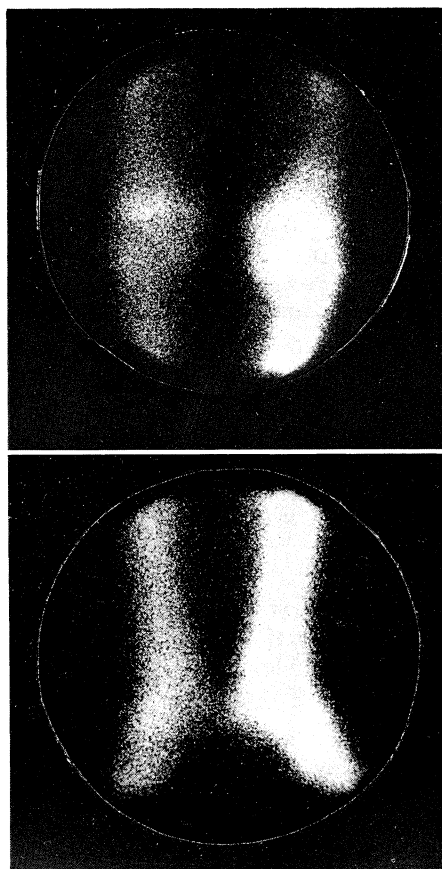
b. Bone scintigraphy showed markedly increase activity in the entire left tibia and foot bone.
